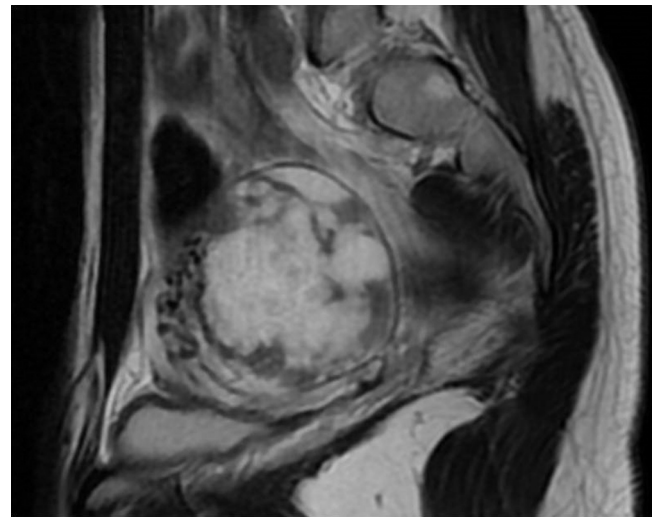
Unenhanced MRI (sagittal). Central area of the tumor shows high intensity suggesting an edematous stroma of the tumor. Low intensity part of the tumormay correspond to fibrous tissue.
